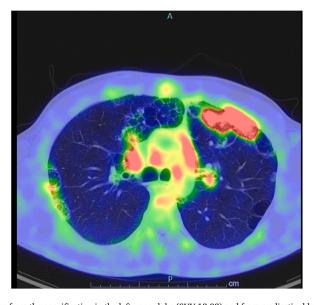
Chest PET SCAN with signal uptake from the opacification in the left upper lobe (SUV 13.83) and from mediastinal lymph nodes in the aortopulmonary region (SUV 4.46), paratracheal (SUV 4), sub-carinal (SUV 5.34) e hilar regions bilaterally (SUV 4.82).
